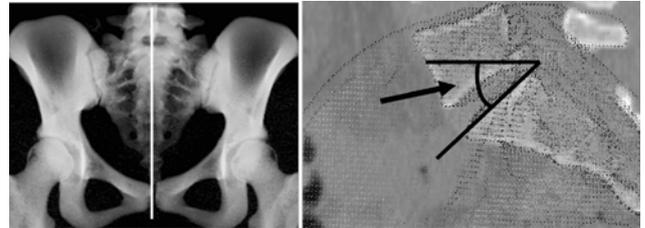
a) Anteroposterior radiograph of pelvis. The white line shows the plane which is through the center of the sacrum with the APP angle being 0° . b) Sagittal plane which is through the center of the sacrum with the APP angle being 0° . The true SS angle, which was measured in this plane, is shown by an arrow
